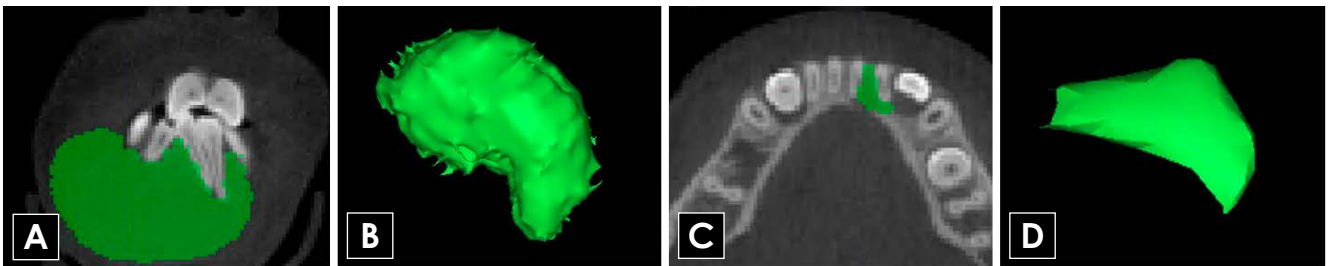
Volumetric analysis of the largest (A, B) and smallest (C, D) CGCG lesions in this study. Coronal (A) and axial (C) CBCT images of CGCG demarcated and filled to reconstruct the 3-dimensional structure (B: 31,347.0 mm³, D: 33.5 mm³). CGCG: central giant cell granuloma, CBCT: cone-beam computed tomography.
